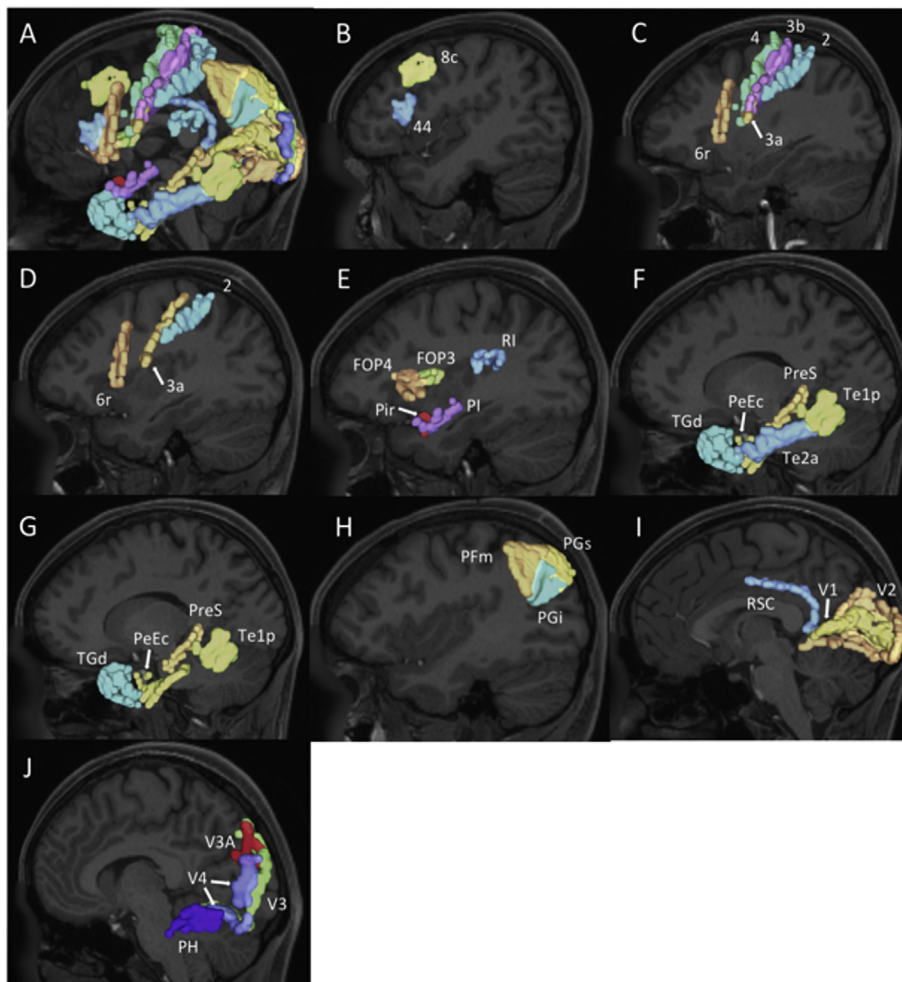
Cortical distribution of all twenty-seven regions defined as having high average strength. These regions are plotted on sagittal T1-weighted images using a representative subject brain derived from the Human Connectome Project database. (A) All high strength regions are shown unlabeled. (B-J) High strength regions are labeled on sagittal MRI cross-sections and organized into clusters: lateral frontal lobe cluster (B), sensorimotor cluster (C), sensorimotor cluster excluding areas 3b and 4 (D), insula cluster (E), temporal lobe cluster (F), temporal lobe cluster excluding area TE2a (G), inferior parietal lobe cluster (H), medial occipital lobe cluster (I), and a lateral occipital lobe cluster (J).
